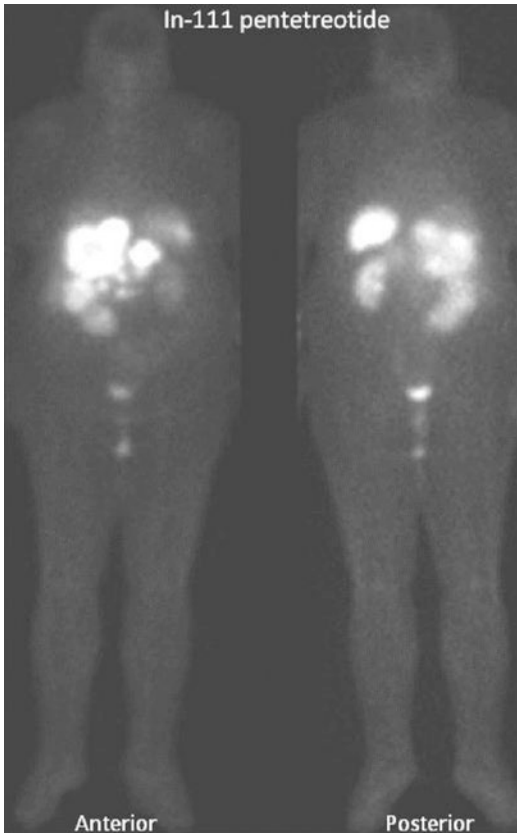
Fifty-three-year-old female presented with carcinoid symptoms for 6 months. She was found to have metastatic disease to the liver and pancreas. In-111 pentetreotide anterior and posterior whole-body planar images at 24 h. Images reveal multiple foci of increased activity in the liver and abdomen consistent with SSTR-positive metastatic disease. SPECT/CT would better locate the abdominal disease
